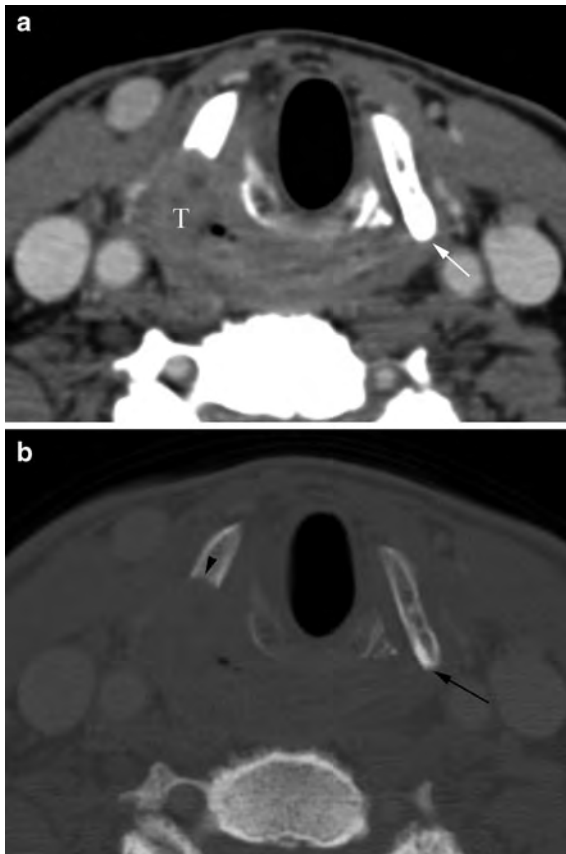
Axial contrast-enhanced CT images displayed in soft tissue (a) and bone (b) windows show severe foreshortening of the posterior thyroid cartilage caused by extensive pyriform sinus cancer (T) involvement on the right, when compared to its normal length on the left (arrow)
